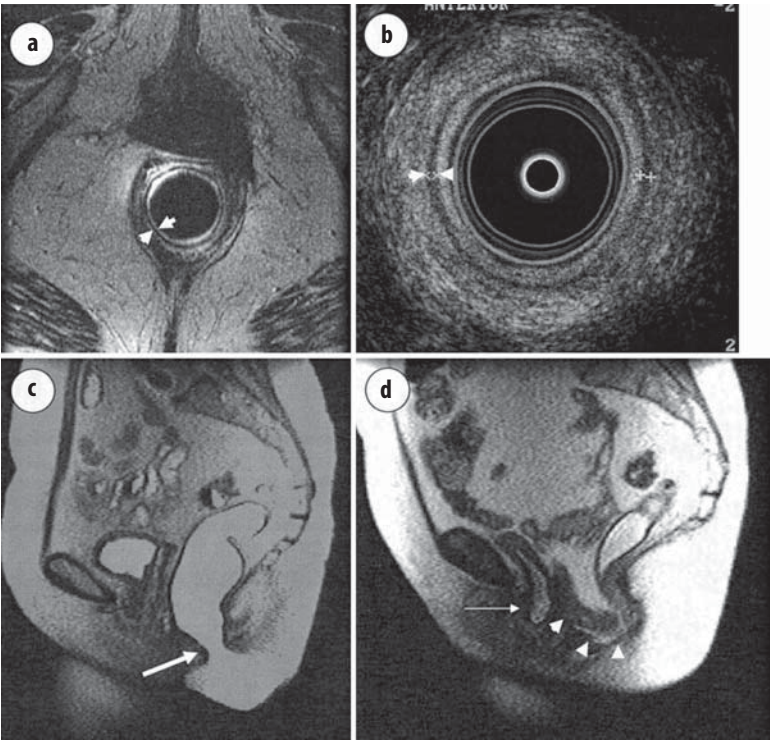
Endoanal T2-weighted fast spin echo imaging of the anal sphincters demonstrates marked diffuse thinning of the internal anal sphincter (arrowheads, a), along with correlative endoanal ultrasound (arrowheads, b). Dynamic MR proctography images at rest (c) demonstrates a patulous anal canal at rest (arrow). Dynamic MR proctography images during defecation (d) show a large enterocele (arrowheads), with mesenteric fat and small bowel.
